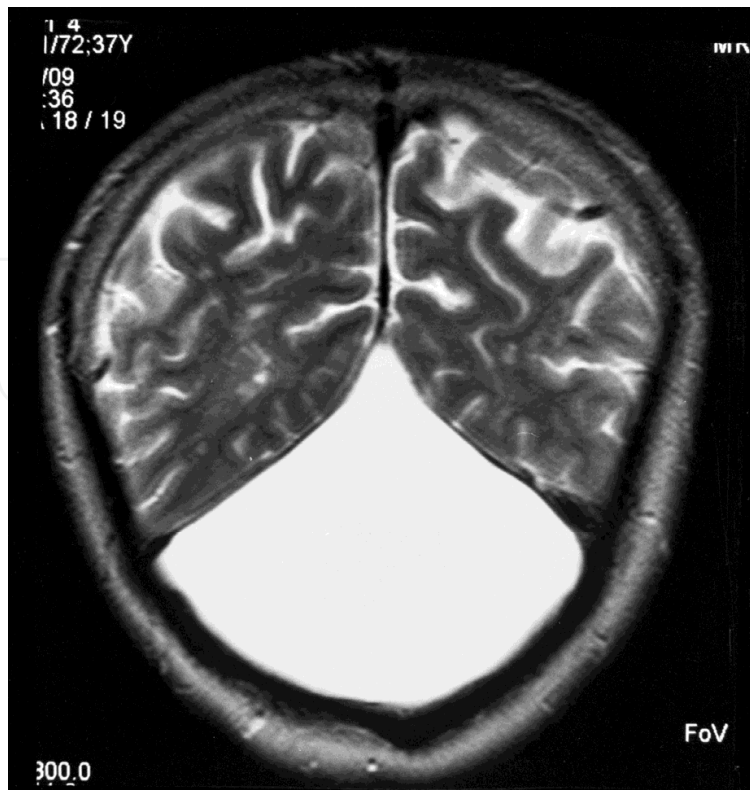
MRI of the brain: Axial T2-weighted image shows large cystic formation.
